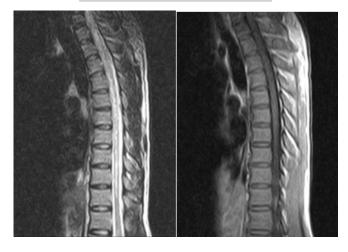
MRI Dorso lumbar spine with contrast (A) T2 SAGGITAL view (B) T1 SAGGITAL view
